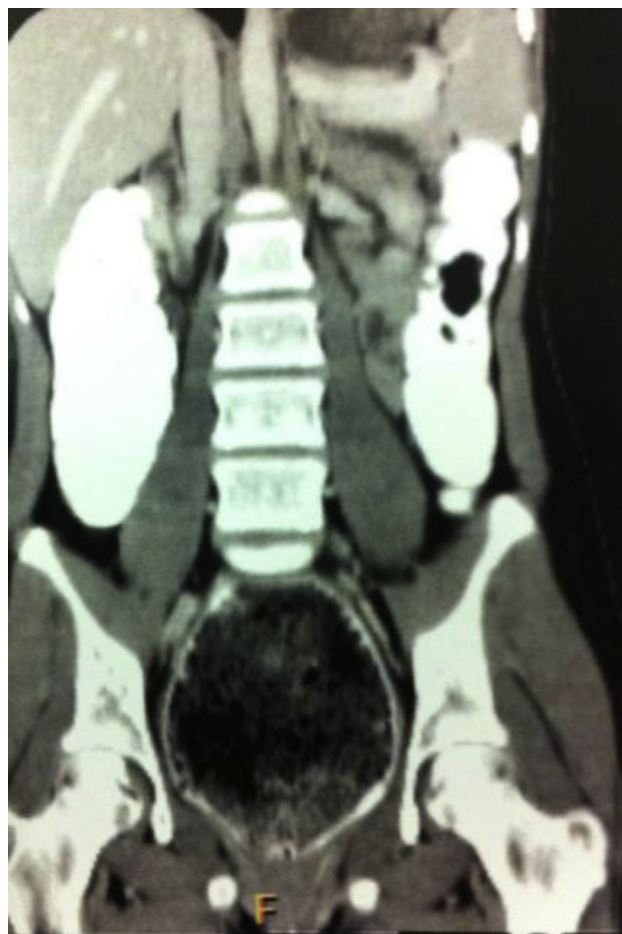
Computed tomography (coronal plane) showing rectal fecal impaction with megarectum.
